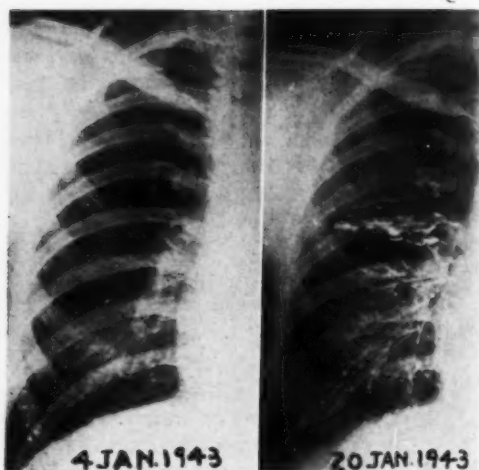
Case 1: Roentgenogram, Jan. 4, 1943; bronchogram, Jan. 20, 1943.
